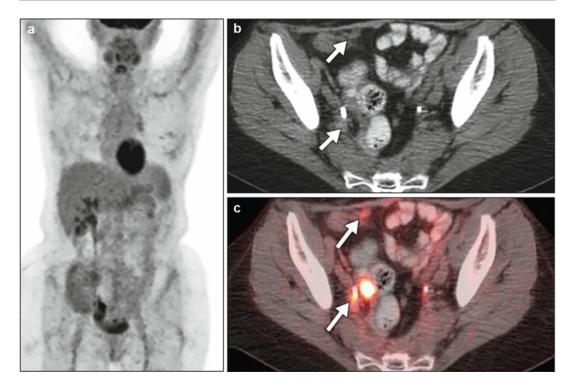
Recurrence in 50-year-old woman with very low carcinoembryonic antigen (CEA) level who had undergone surgery and chemoradiation for treatment of adenocarcinoma of rectum. Patient underwent [¹⁸F]FDG-PET/CT for restaging. (a-c) Anterior maximum intensity projection (a), axial CT (b), and fused PET/CT (c) images. Fused PET/CT image shows metabolically active (standardized
